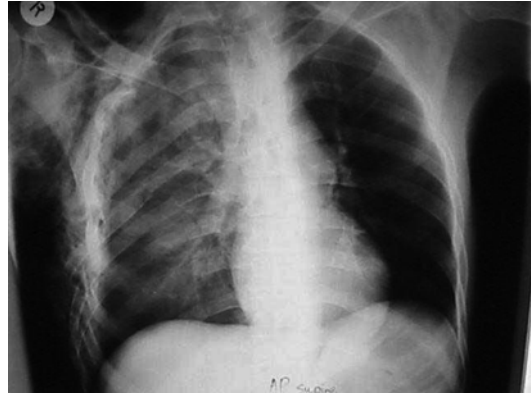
Chest radiograph with a right-sided flail chest injury: multiple segmental rib fractures and a pulmonary contusion are evident
